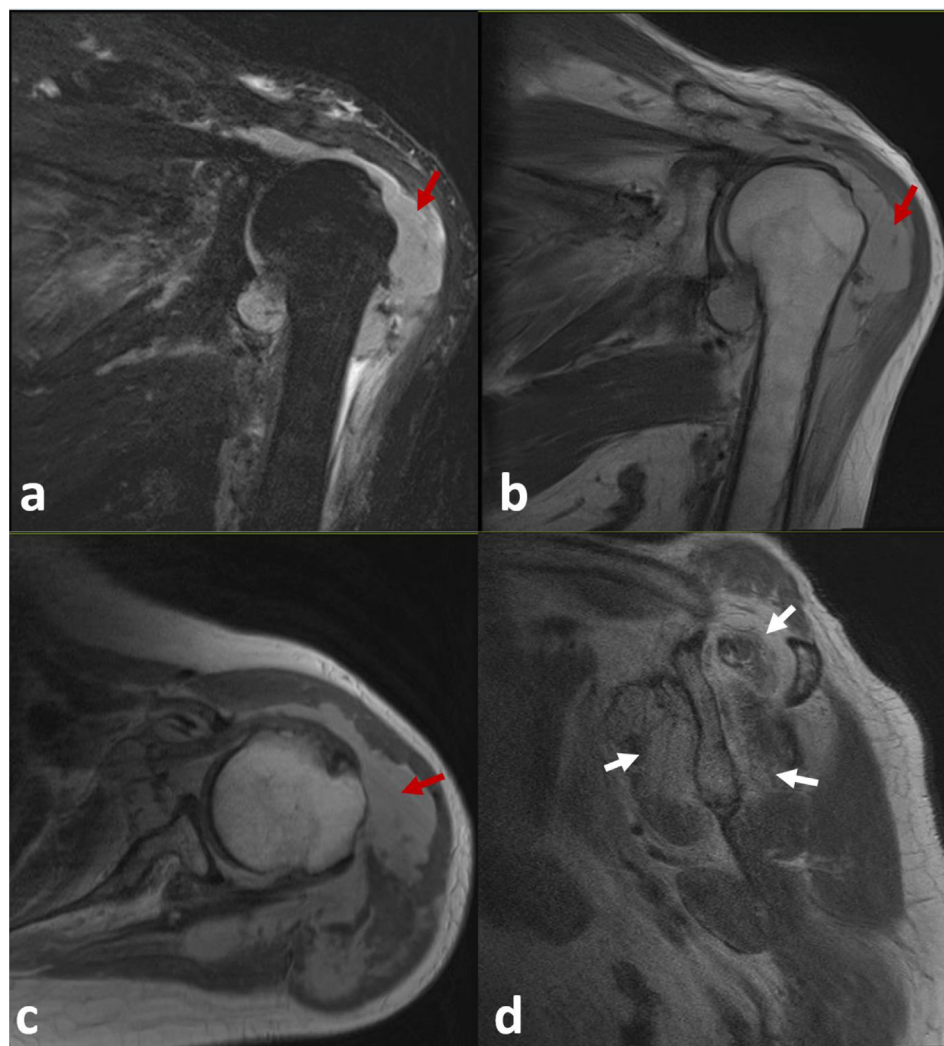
Magnetic resonance imaging (MRI) of the patient's left shoulder taken one week after vaccination on initial presentation. 2a (Coronal T2 Dixon sequence), 2b (Coronal PD BLADE sequence) and 2c (Axial TSE-PD sequence) shows the massive shoulder joint effusion (annotated with red arrows) with synovitis, communicating with the subdeltoid and subacromial bursa. 2d (Sagittal TSE-PD sequence) shows the chronic rotator cuff tears of the supraspinatus, infraspinatus and subscapularis (annotated in white arrows) with muscle atrophy.
